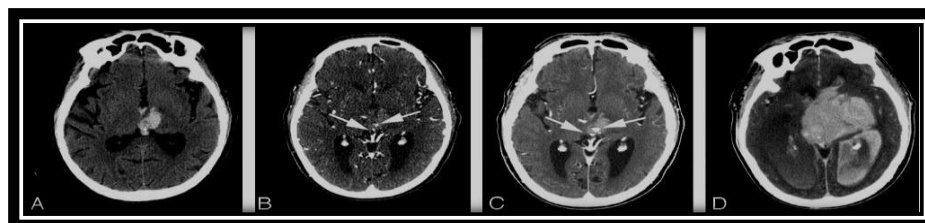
69-year-old hypertensive man underwent imaging 2 hours following onset of right-sided paralysis. (A) Admission NCCT demonstrates left thalamic hematoma with extension of hemorrhage into the third ventricle. After 24 hours CTA (B) and CECT (C), respectively, were done and showed 2 foci of active extravasation (arrows); positive spot sign. (D) Follow-up NCCT 48 hours later shows marked hematoma growth with hemorrhage in both lateral ventricles and severe hydrocephalus.
